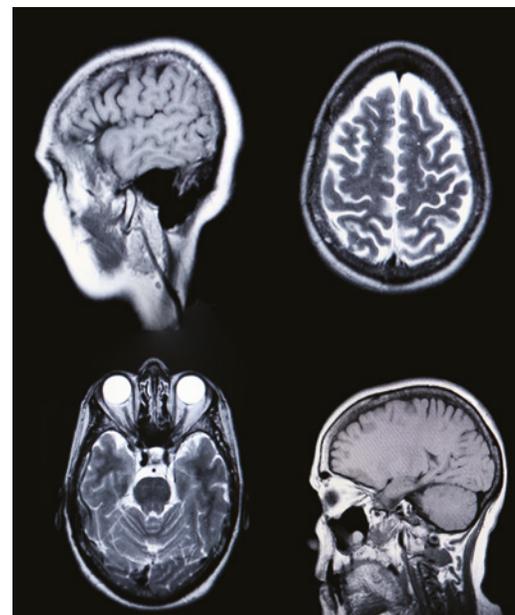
The MRI provides a highly detailed 3D image of the brain that can be examined in cross-sections. It shows the structure of the brain and is powerful in enabling the detection of small tumours or changes in the brain.
